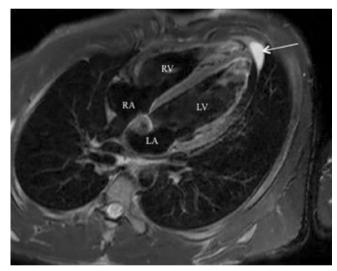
Cardiac MRI of a pericardial cyst (white arrow), anterior to the right heart chambers. RA right atrium, RV right ventricle (courtesy of MS. Cohen, MD). LA left atrium, LV left ventricle, RA right atrium, RV right ventricle
